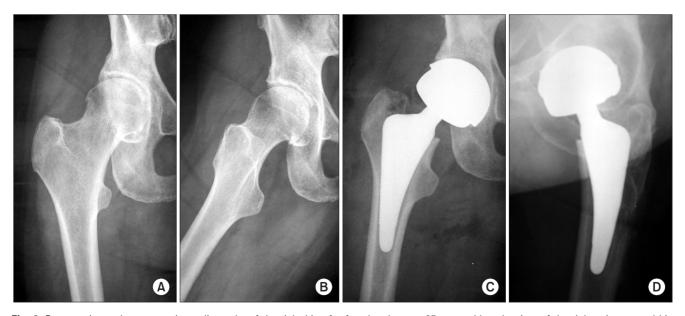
Preoperative and postoperative radiographs of the right hip of a female who was 65 years old at the time of the right primary total hip replacement. (A and B) Preoperative anteroposterior and lateral radiographs demonstrating osteoarthritis of the hip with partial loss of the joint space and formation of osteophytes. (C and D) Anteroposterior and lateral radiographs at 2 years after total hip replacement with use of a cementless hip Balance Microplasty Stem (Biomet) and a M²A-Magnum (Biomet) metal-on-metal acetabular component. Note the excellent osseointegration and absence of radiolucent lines at the implant-bone interface.
